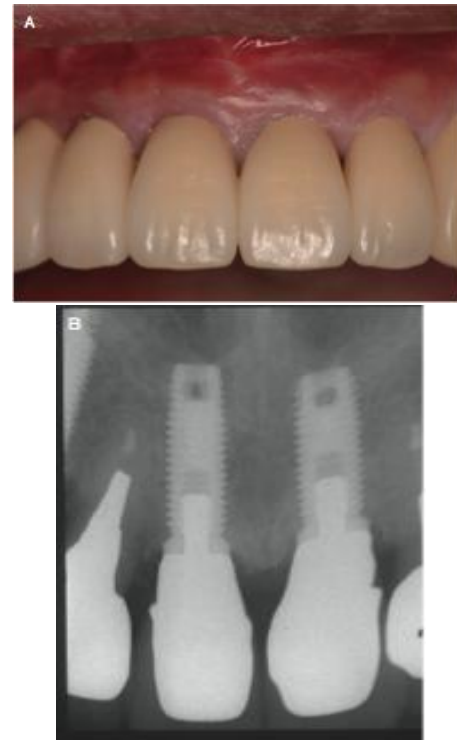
Five-year follow-up. Frontal view. Note the stable level of the peri-implant tissue; B radiograph at the 5-year follow-up. Only minor remodeling of the hard tissue is seen. Note the stable bone level well above the level of the fixture head.
